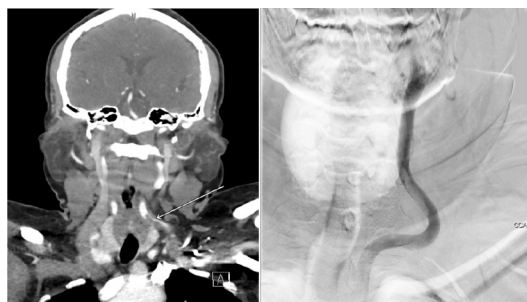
Left common carotid macrothrombosis on CT angiography and left carotid injection on digital subtraction angiography.
